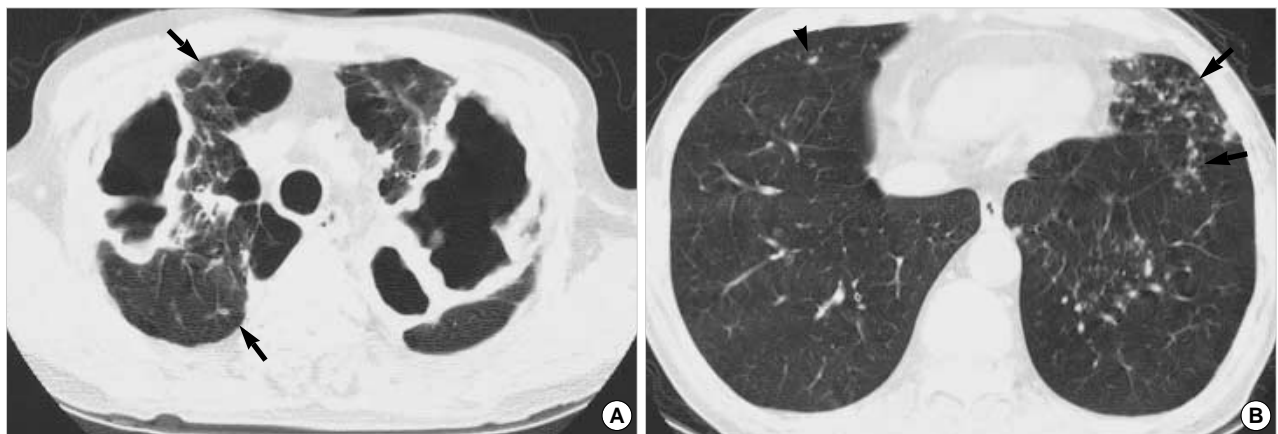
A 66-yr-old man with *M. avium-intracellulare* complex pulmonary disease. (A) Transaxial thin-section (2.5-mm thickness) CT scan obtained at level of great vessels shows multiple large thin-walled cavities in both lung apices. Also note several small nodules (arrows) in right lung. (B) CT (2.5-mm thickness) scan obtained at level of suprahepatic inferior vena cava shows multiple small nodules and branching centrilobular nodules, so-called tree-in-bud pattern (arrows), in lingular segment of left upper lobe and left lower lobe. Small nodule (arrow-head) is also seen in right middle lobe.
